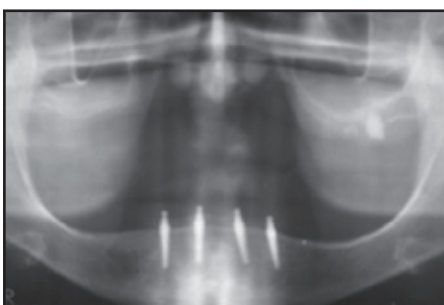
The immediate postoperative panoramic radiograph
